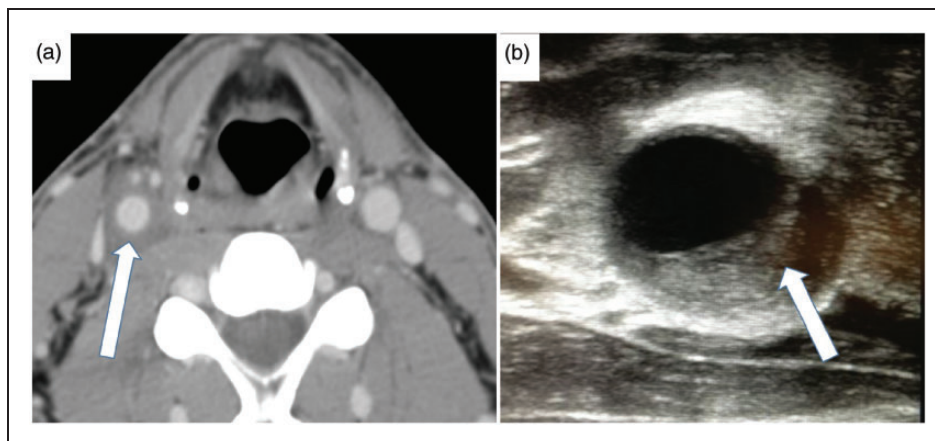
(a) T-1 magnetic resonance image showing a symmetrical inflammatory tissue density (arrow) surrounding the right common carotid artery; (b) Duplex ultrasound of the carotid artery showing perivascular inflammatory tissue density (arrow) surrounding the internal carotid artery.
